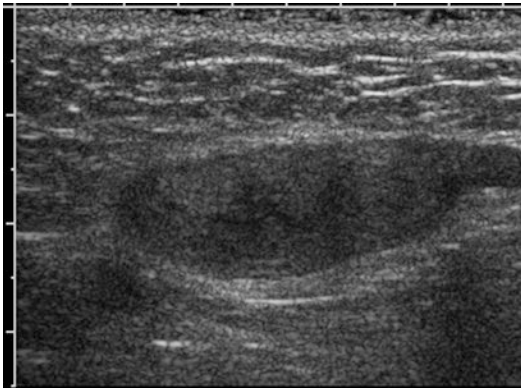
Undescended testis: longitudinal sonogram shows a small, hypoechoic testis in the inguinal canal
